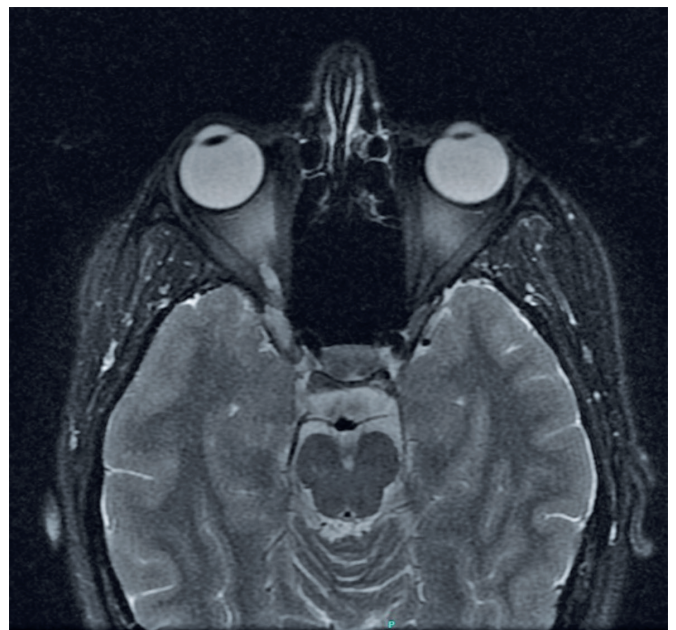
Magnetic resonance imaging confirming cavernous sinus thrombosis.
